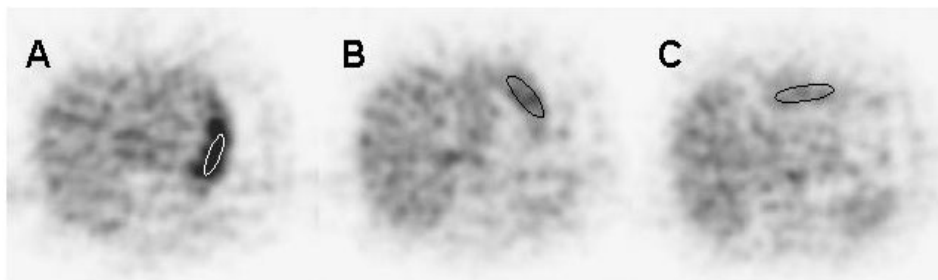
An example of the regions of interest in a patient (patient No. 3). Elliptical regions of interest were placed on the Upper area (A), Middle area (B), and Lower area (C) of the stomach, and then the SUVs of each area were determined.
